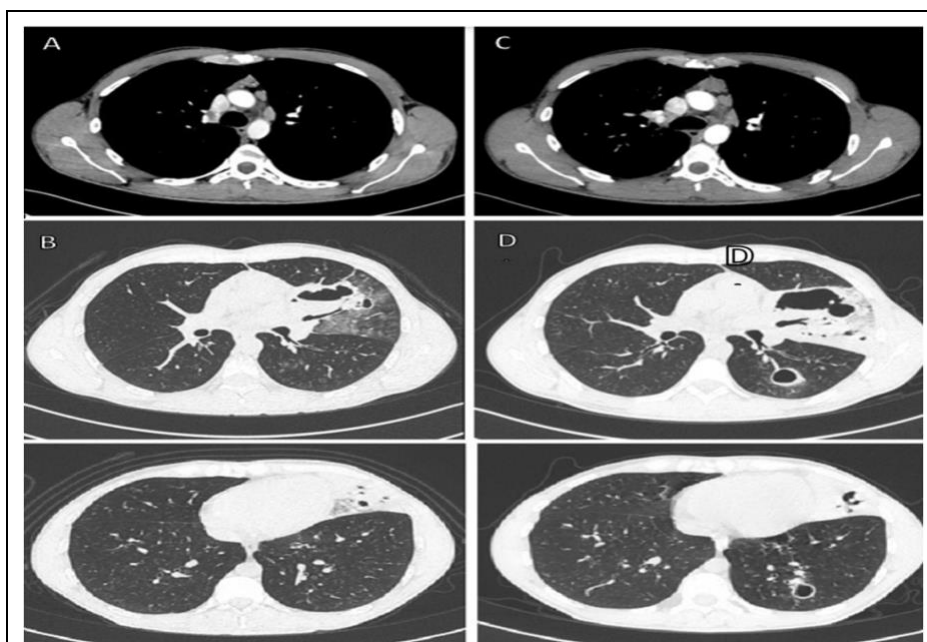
A+B: Chest CT scan showing adenomegalies in anterior mediastinal chain (A) and a cavitary and irregular consolidation in the lingular region of the lung, surrounded by ground glass opacities (B). C+D: Chest CT scan performed six months later, showing an increase in the size of the adenomegalies (C) and the persistence of the consolidation in the lingula, with an increase in the size of excavations within this area and the emergence of new excavated nodules in the lower left lobe (D).
